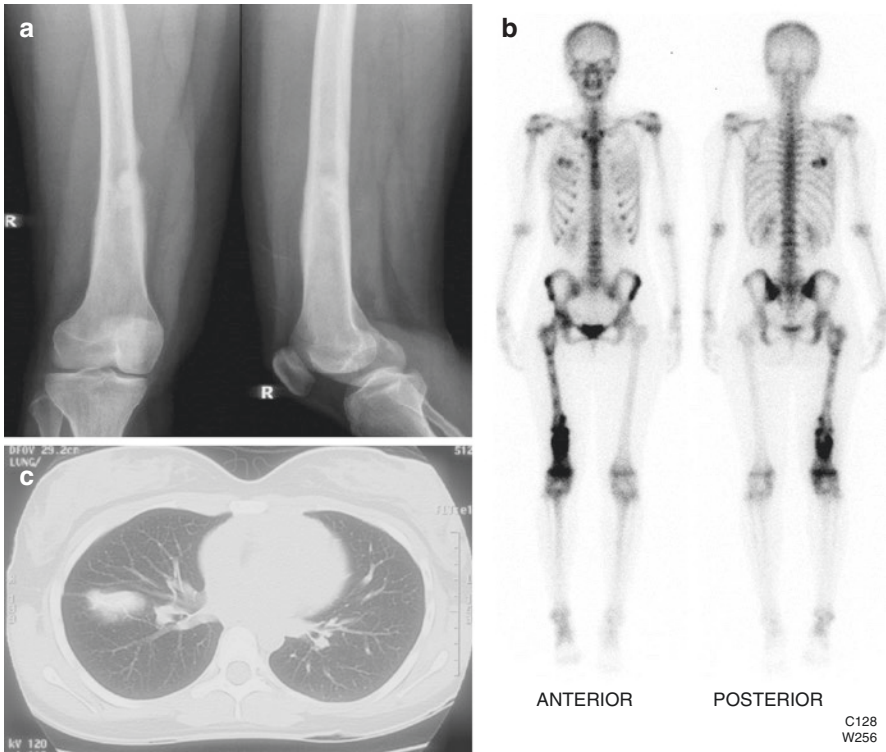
(a) Plain X-ray demonstrating changes typical of osteogenic sarcoma of the right femur. (b) Delayed whole bone scan showing the tumour extending to involve the proximal right femur with uptake involving the right chest consistent with an osteogenic metastasis. (c) Axial CT slice of the chest confirming intra-parenchymal lung metastasis
